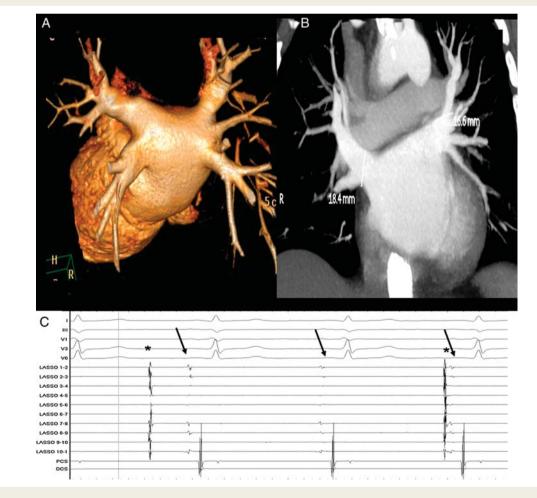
Figure I Computed tomography scan. (A) Details of the left atrial and pulmonary veins anatomy. (B) Measurement of the pulmonary vein diameters. (C) Intracardiac electrograms after pulmonary vein isolation showing complete dissociation between the pulmonary vein (asterisk) and the atrial potentials (arrows).
